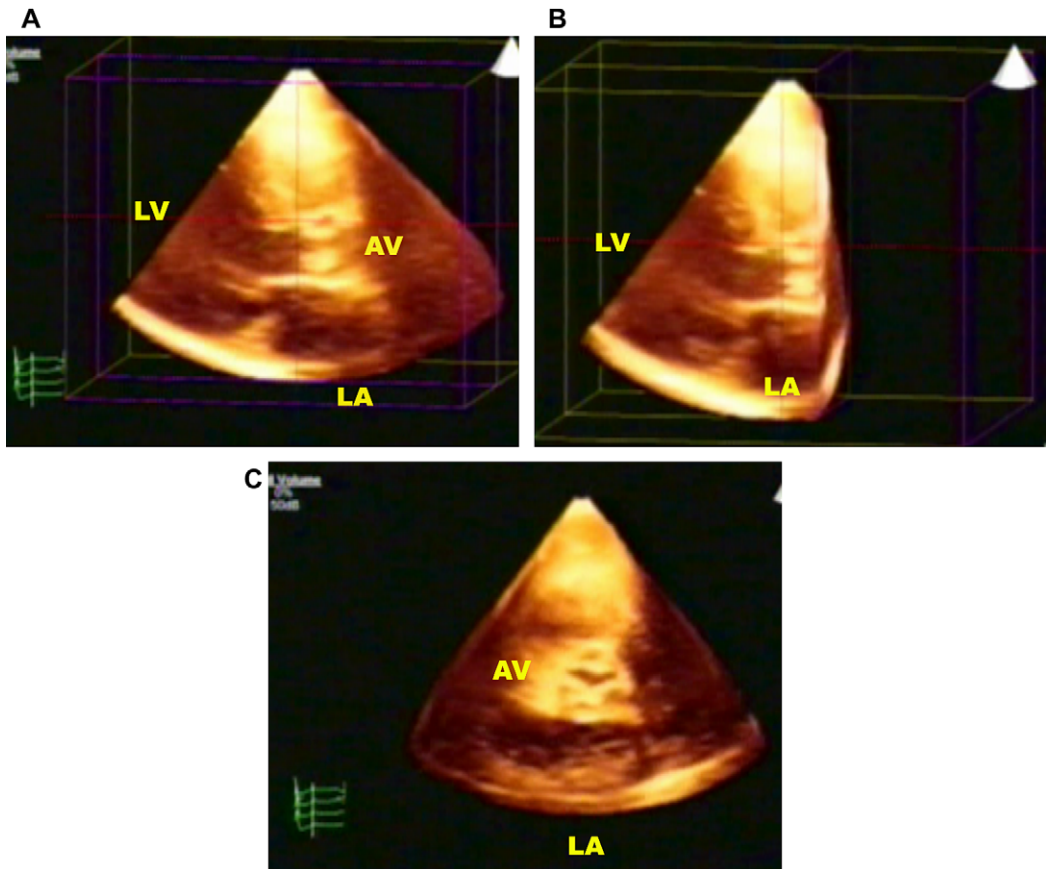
Live, real time 3D echocardiography in aortic stenosis. (A) The aortic valve (AV) is viewed in the parasternal long-axis view showing calcified leaflets. The data set then was cropped from right to the level of the flow-limiting tip of the AV leaflets (B) and rotated en face to view the very narrow aortic orifice in short axis consistent with severe stenosis (C). The patient has the so-called acquired bicuspid aortic valve because of fusion of two of the three cusps. *Abbreviations:* LA, left atrium; LV, left ventricle.
